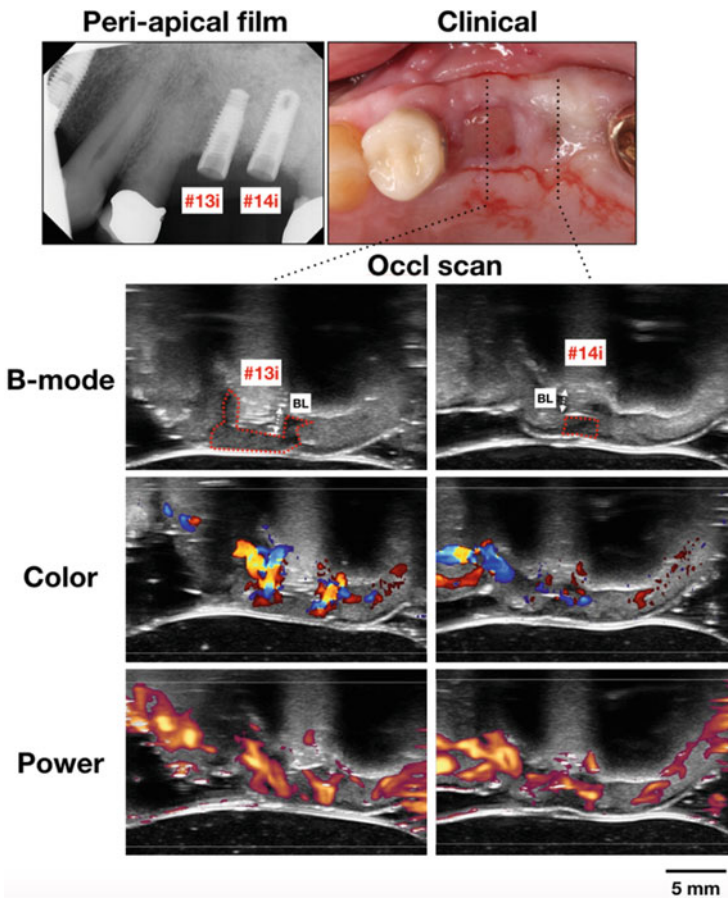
A clinical case with compromised implant healing. The B-mode occlusal scans show intensity changes in soft tissue around the implants, indicating loss of collagen and matrix structures due to inflammation. Bone loss (BL) is evident in this view direction, corresponding to the amount of bone loss on the 2D radiograph. Overt blood flow is seen on color (middle) and power Doppler (bottom) images, indicative of tissue inflammation
